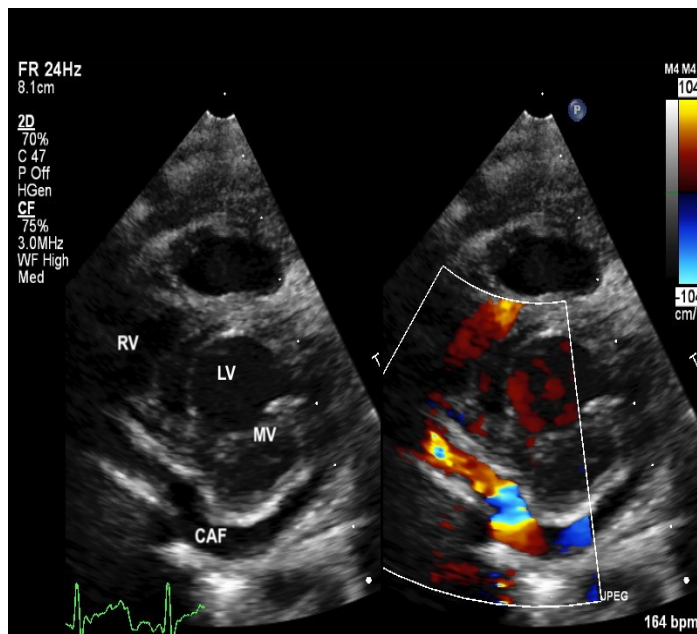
Short axis parasternal view demonstrating the insertion of the coronary artery fistula into the right ventricle. (RV – right ventricle, LV – left ventricle, MV – mitral valve, CAF – coronary artery fistula).
